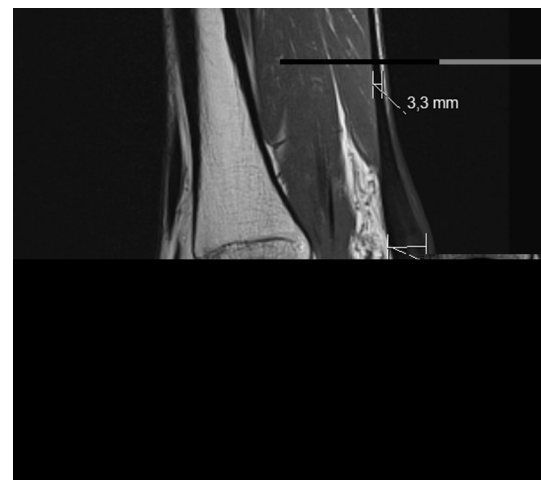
Pre-op MRI showing measurement locations in the sagittal plane
